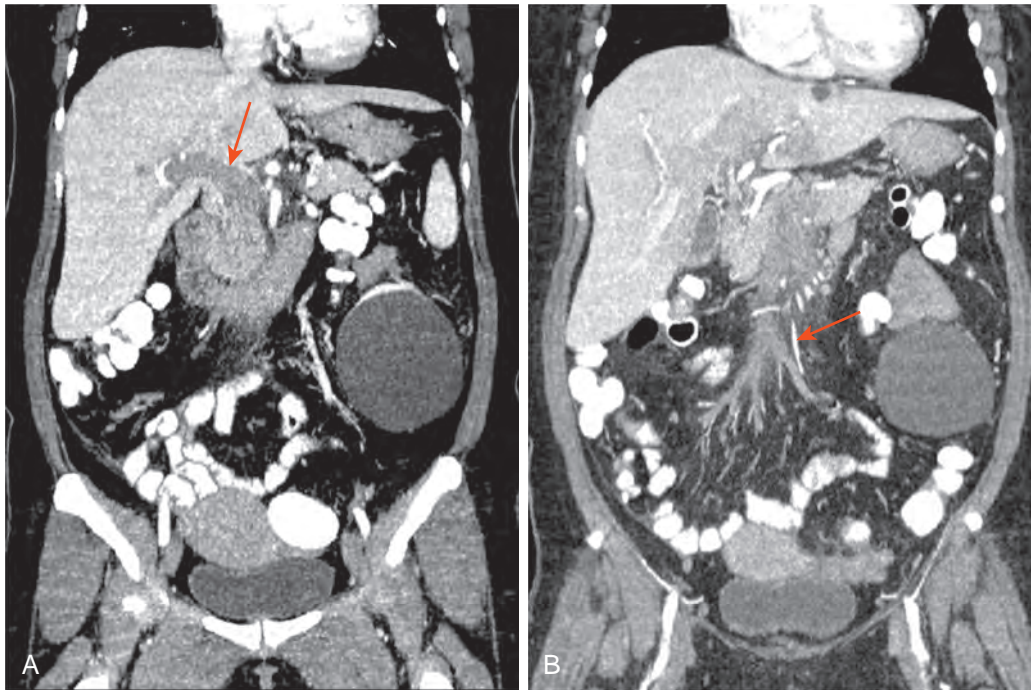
Portal and superior mesenteric vein thrombosis: CT findings. A. Coronal, reformatted MDCT image shows thrombus (arrow) in the main portal vein in this patient with a coagulopathy. B. Coronal reformatted image, anterior to A, demonstrates the thrombus extending into the superior mesenteric vein and its branches.
